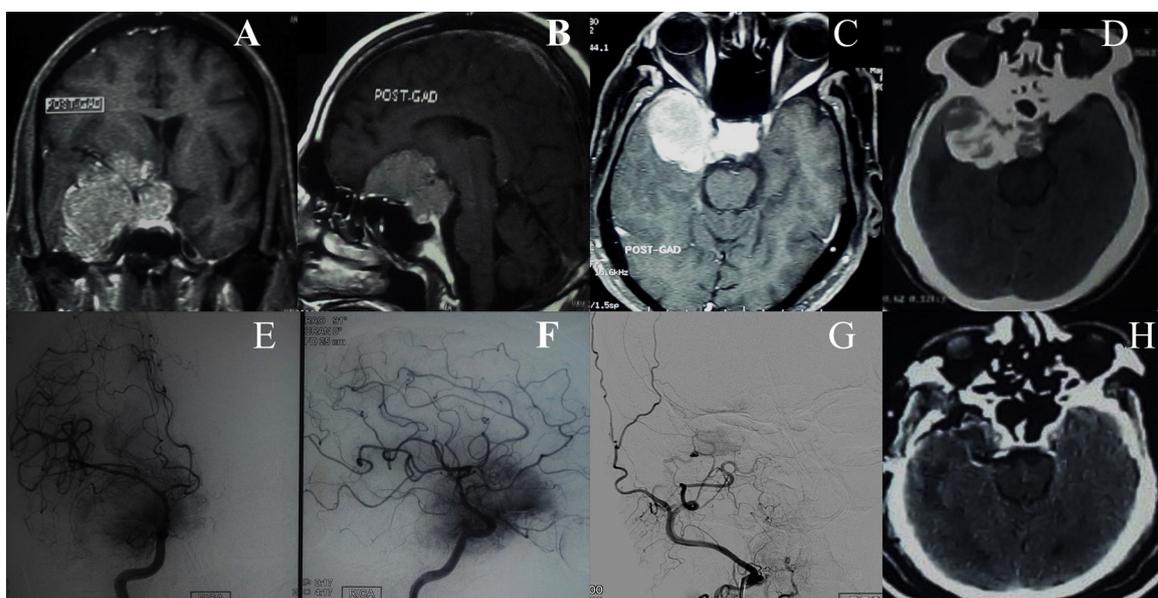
A–C) Preoperative Contrast MRI demonstrating clinoid meningioma with encasement of ICA as well as A1 and M1 D) Preoperative NCCT scan showing hyperdense lesion E & F) DSA (AP & lateral) showing moderate blush of tumor from ICA with narrowing of ICA at bifurcation G) DSA with ECA injection showing no blush H) postoperative NCCT showing GTR.
